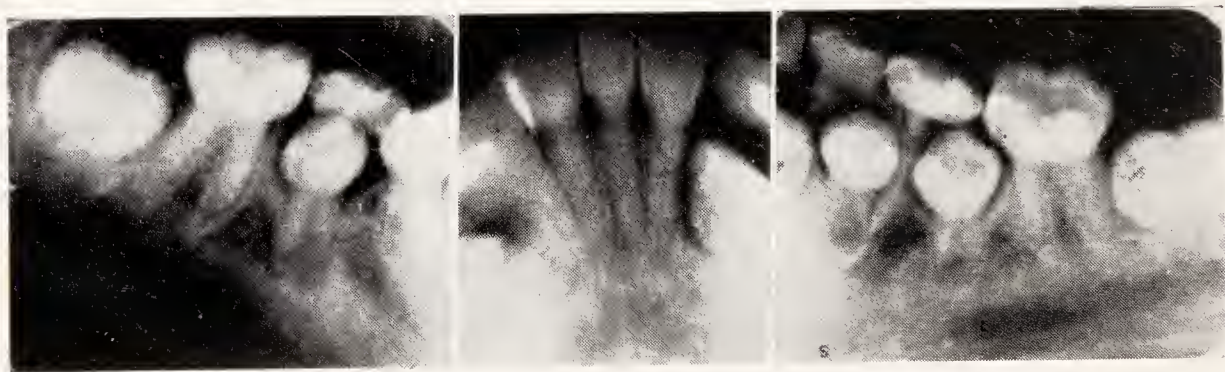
Radiographs of the mandibular teeth of a child, aged seven, with hereditary opalescent dentin. The teeth are grayish-brown and translucent. Note the absence of pulp chambers in the lower incisors, bicusps, and first permanent molars. The molar roots are short and pointed. Most of the members of this family were similarly affected. (Courtesy of O. J. McCormack.)
